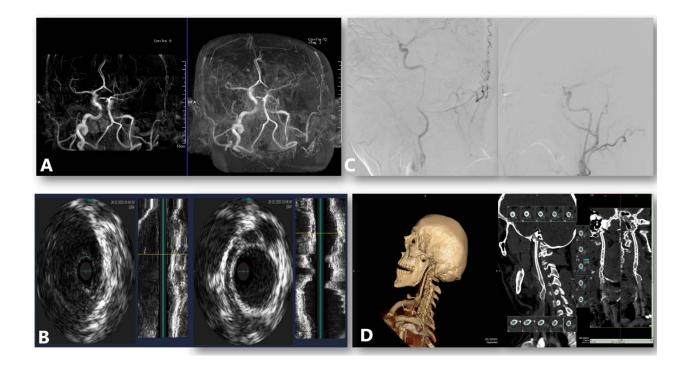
A. Magnetic resonance tomography which showed dissection in the distal part of the left internal carotid artery. Significant stenosis with a filiform lumen of the extracranial segment of the distal left internal carotid artery 55 mm from the bifurcation along 42 mm to the level of pars petrosis was visualized. A hematoma in a late subacute joint is depicted near the lumen of the vessel in this area. B. An IVUS examination was performed with lesion interrogation. C. Carotid angiography confirmed the occurrence and localization of dissection. D. Nuclear magnetic resonance imaging of the head on follow-up shows normal blood flow bilaterally
